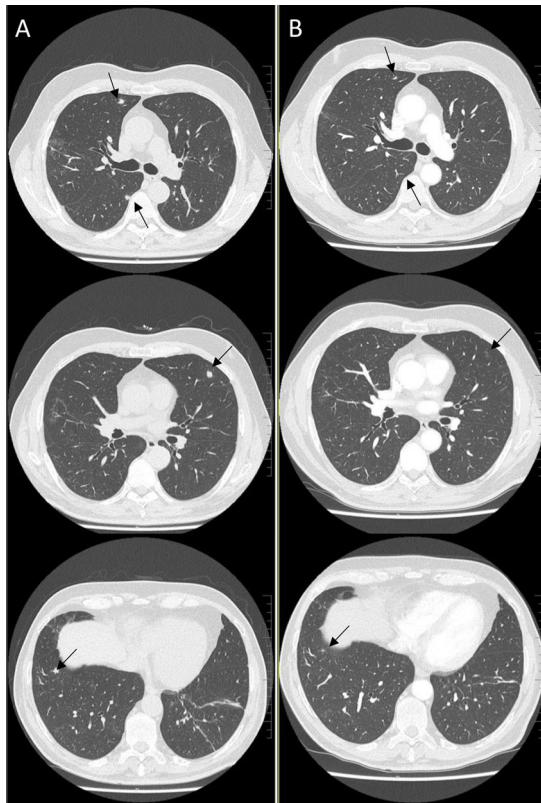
High-resolution computed tomography (A) showing multiple pulmonary nodules measuring less than 1 cm (black arrows) with partial resolution at 3 months (B).
